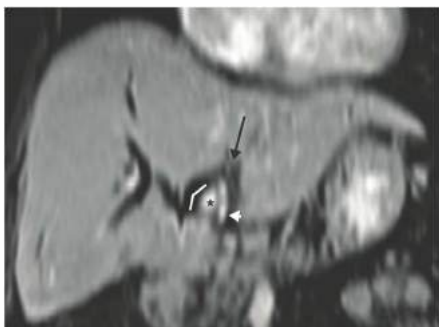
• Coronal MRI showing the relationship between the left hepatic duct (*bent white line*) and the left portal vein (*asterisk*). The duct lies anterior–superior to the left portal vein at the base of segment 4. The left hepatic artery (*white arrowhead*) runs along the left side of the hepatoduodenal ligament and joins the duct and vein at the base of the umbilical fissure (*black arrow*).
